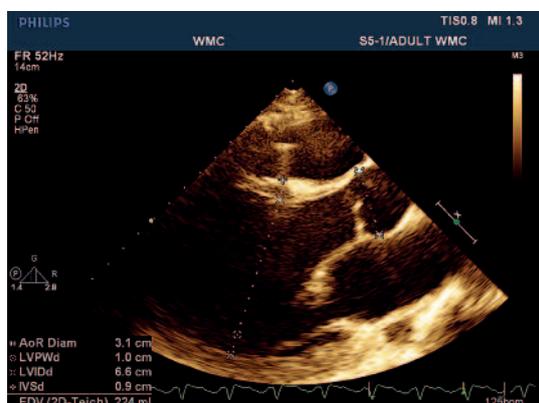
This figure is a 2-dimensional echocardiogram showing a dilated cardiomyopathy. The left ventricular internal dimension at the end of diastole is 6.6 cm
